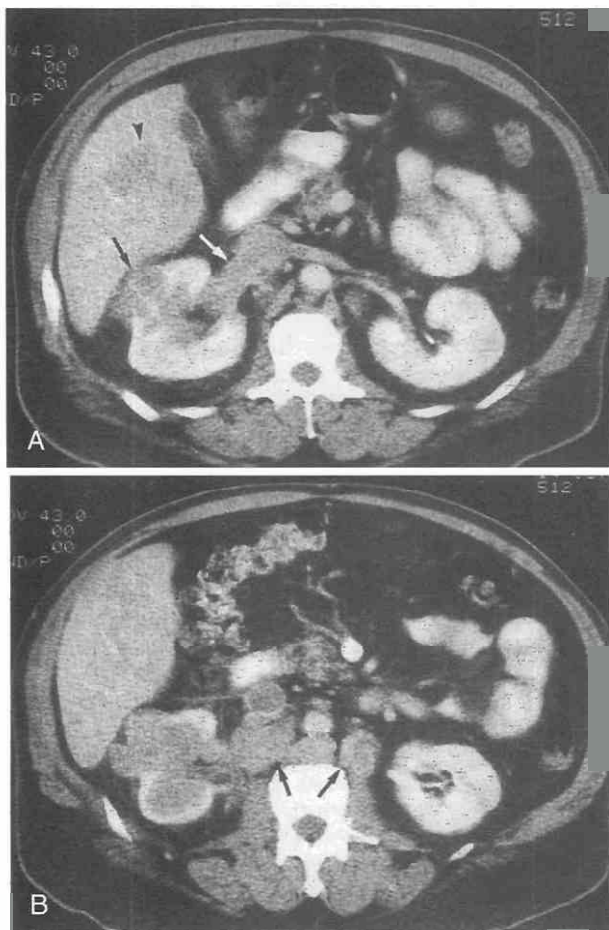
Renal cell carcinoma with venous extension and regional lymph node metastases. *A*, Contrast-enhanced CT scan shows a right renal mass (black arrow). The right renal vein (white arrow) is enlarged and occupied by tumor, which has also extended into the inferior vena cava. There is a metastasis in the right lobe of the liver. *B*, Multiple enlarged, central retroperitoneal lymph nodes (arrows) were due to metastatic disease.
